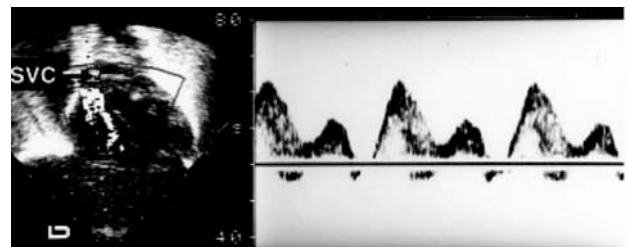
PW-Doppler placed at the SVC right atrial junction, revealing S, D, and A waves of SVC return.
